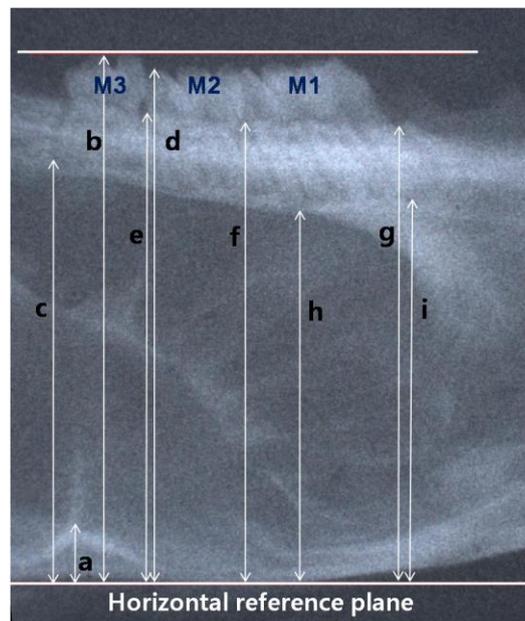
Measurements on periapical film. a, Frontal–squamosal intersection at the temporal crest; b, middle cusp tip of maxillary 3rd molar (M3) – total height; c, M3 distal root apex; d, distal cusp tip of maxillary 2nd molar (M2); e, alveolar crest between M2 and M3; f, alveolar crest between maxillary 1st molar (M1) and M2; g, alveolar crest in M1 mesial side; h, M1 distal root apex; i, M1 mesial root apex.
